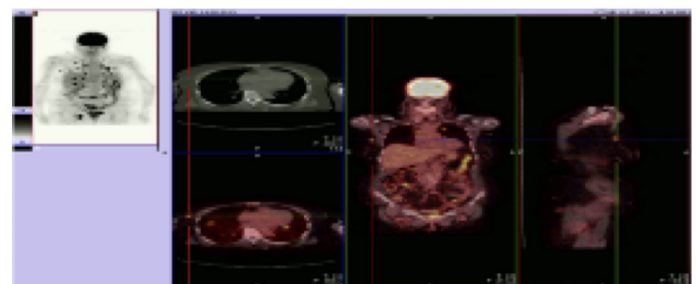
At the time of progression PET CT images
